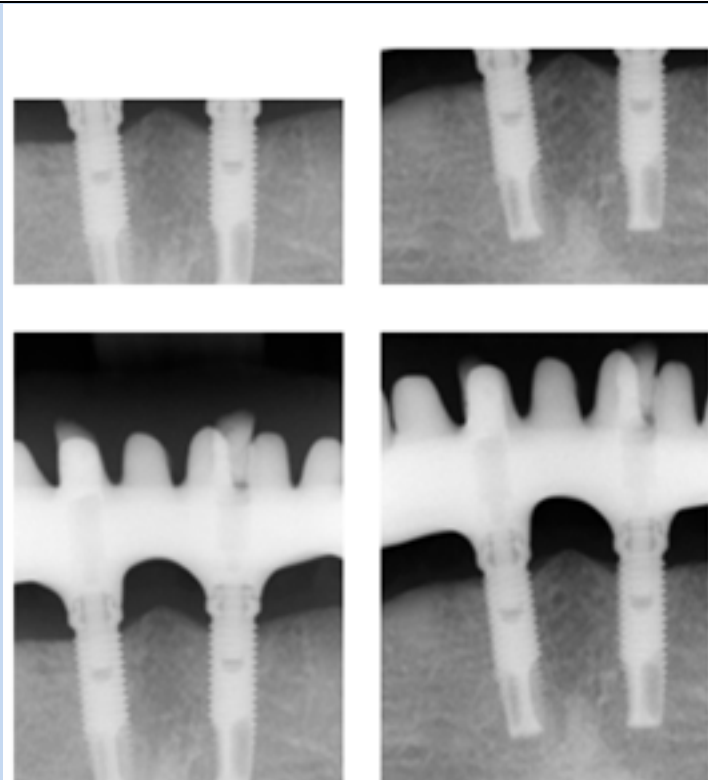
Example of radiographs of the same patient and region from different dates. Upper row; when the supra-construction was masked (Part One). Lower row; when the supra-construction was visible (Part Two). Upper left: masked “ante-mortem”. Upper right: masked “post-mortem”. Lower left: unmasked “ante-mortem”. Lower right: unmasked “post-mortem”
